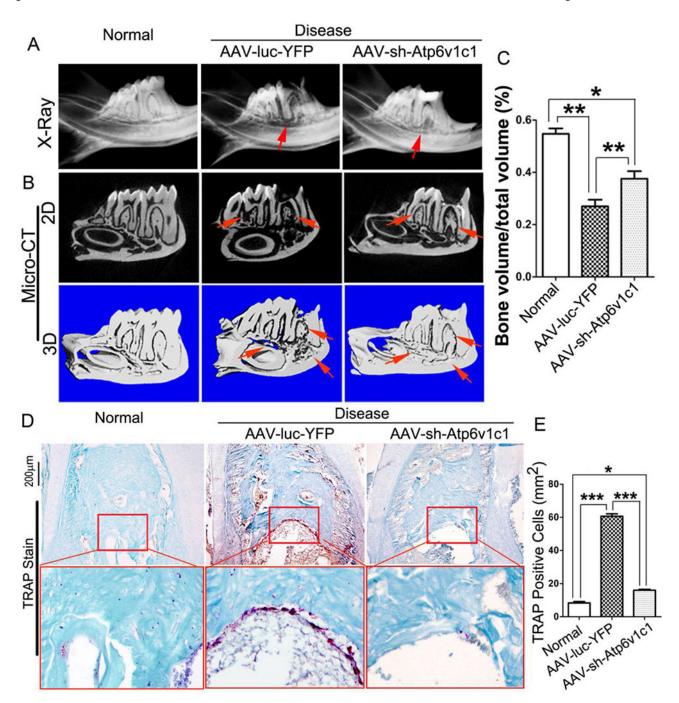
AAV-sh-*Atp6v1c1* impaired osteoclast-mediated bone resorption in the periapical lesion area *in vivo* through reduced osteoclast differentiation.
